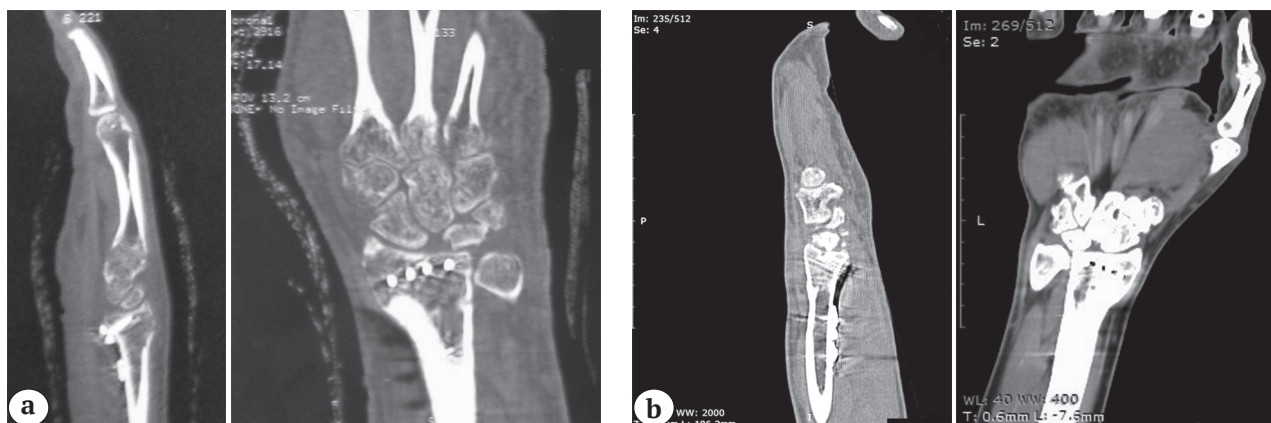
CT of the left wrist (AP and lateral planes) of the 21-year-old patient, after the surgery: a – in 3 months, fusion of the radius along the osteotomy line is noted; b – in 12 months, marked sclerosis and cystic lesion of the pisiform and lunate fossa of the radius.
